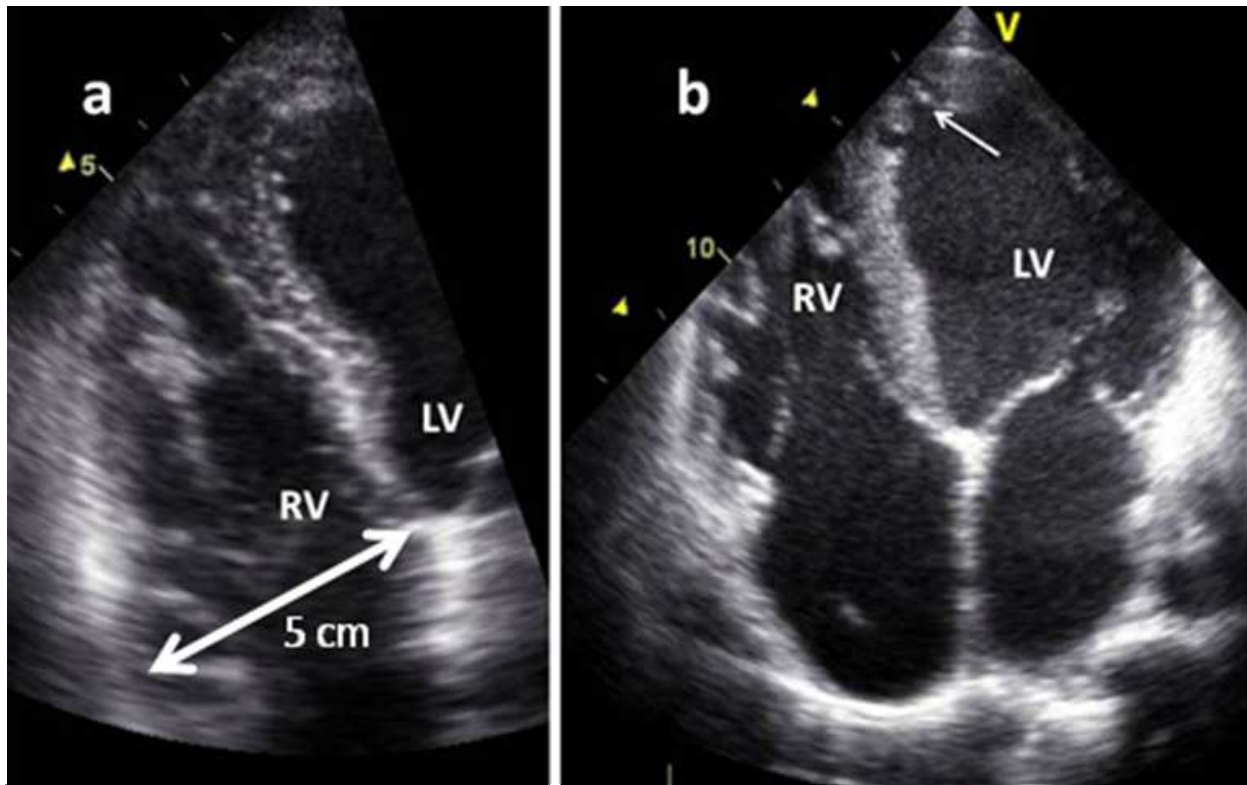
Echocardiographic pictures of 2 patients with arrhythmogenic right ventricular cardiomyopathy.
